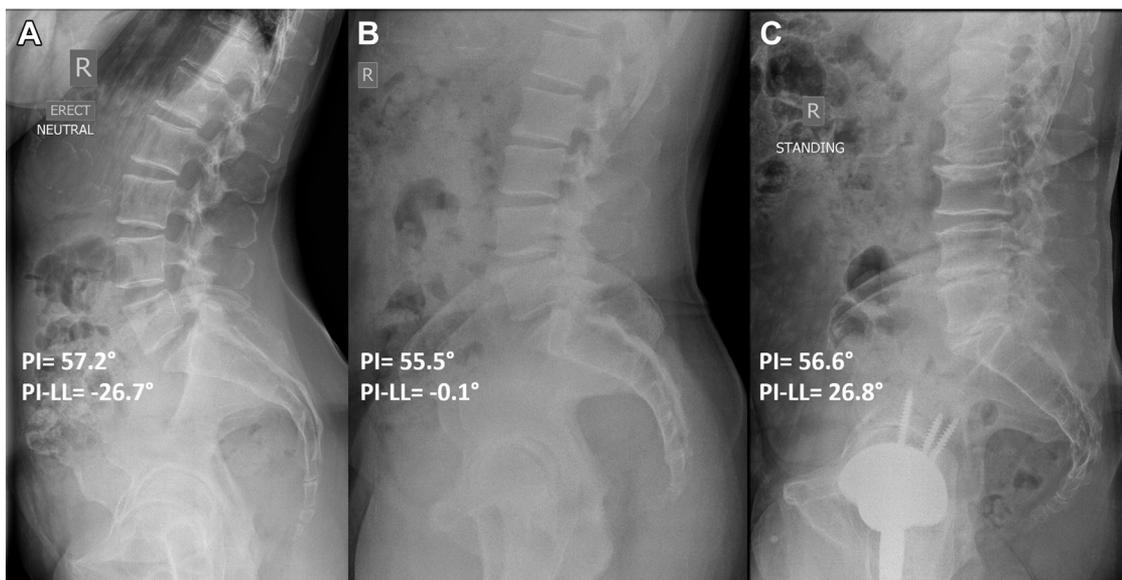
Standing lateral radiographs demonstrating PI-LL mismatch in 3 patients with a similar PI. (A) Hyperlordosis (PI-LL $<-10^\circ$). (B) Balanced (PI-LL = -10° to $+10^\circ$). (C) Lumbar flatback (PI-LL $>10^\circ$).
